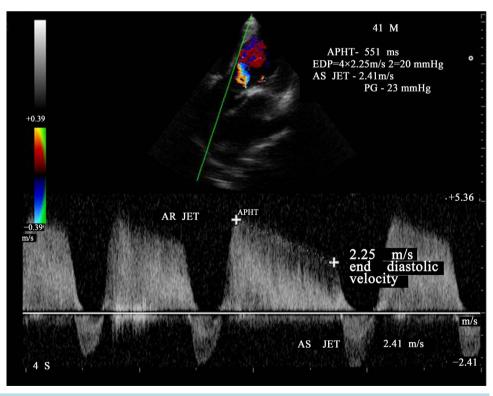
CW doppler imaging showing the AR jet-pressure half-time in long cycle in AF (atrial fibrillation)—flat slope of pressure decay. AS (aortic stenosis) jet.
